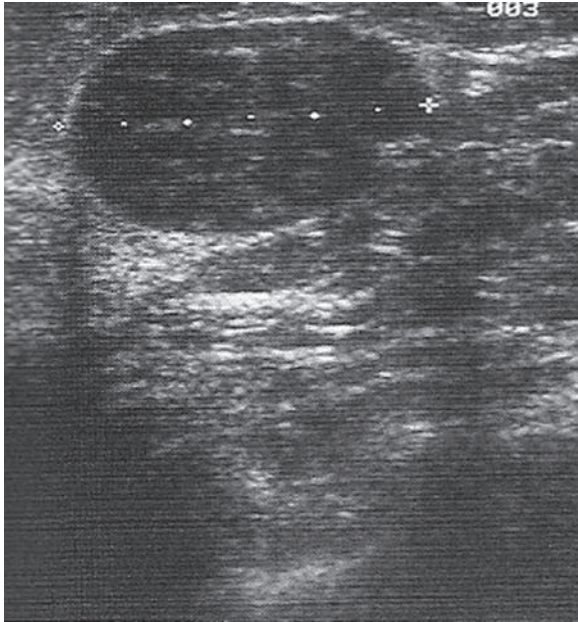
Ultrasound of a fibroadenoma; note the ovoid appearance with the long axis (being measured here) parallel to the skin surface and the well-defined acoustic shadow from the edges of the lesion. Contrast the appearances to those of Fig. 6.12
